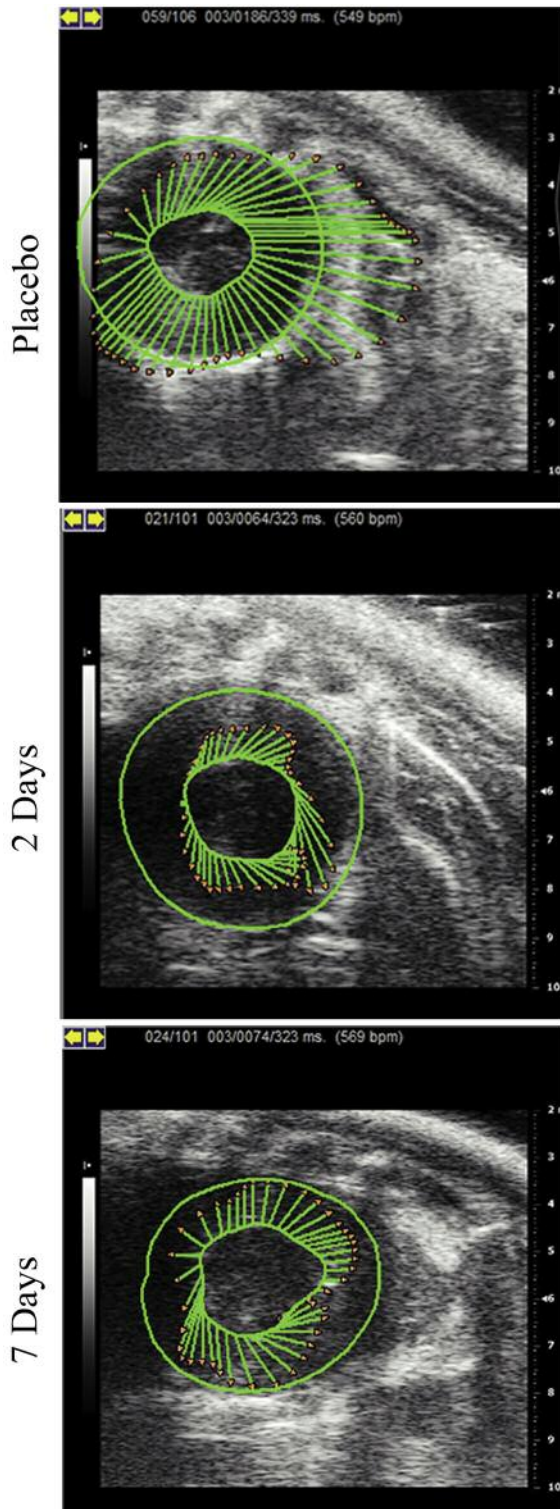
Strain-based vector mapping of cardiac function. Displacement encoding with echocardiographic vector map imaging for regional strain in basal, two days and seven days of treatment. The displacement (length in cm) of vectors was measured as the distance traveled by the kernels from peak diastole to full systole and serial vectors (arrows), reflecting tracking of segmental myocardial deformation during contraction.
